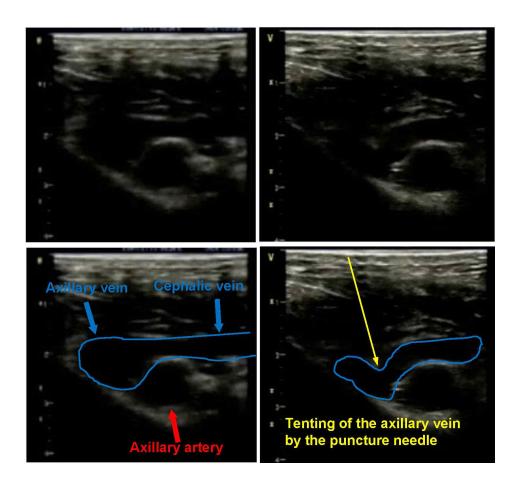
Cross-sectional ultrasound images of the axillary vein. Upper pannel figures are raw ultrasound image and bottom pannel figures are annotated with labels for explanatory purposes in this figures. Note that the tenting of the axillary vein by the puncture needle.
